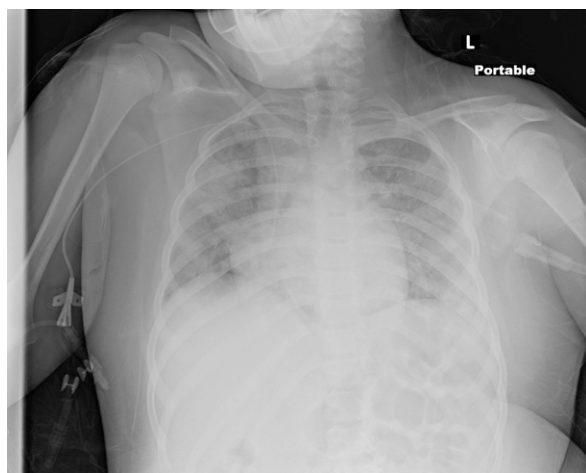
Chest radiograph shows airspace opacities in both lungs.
